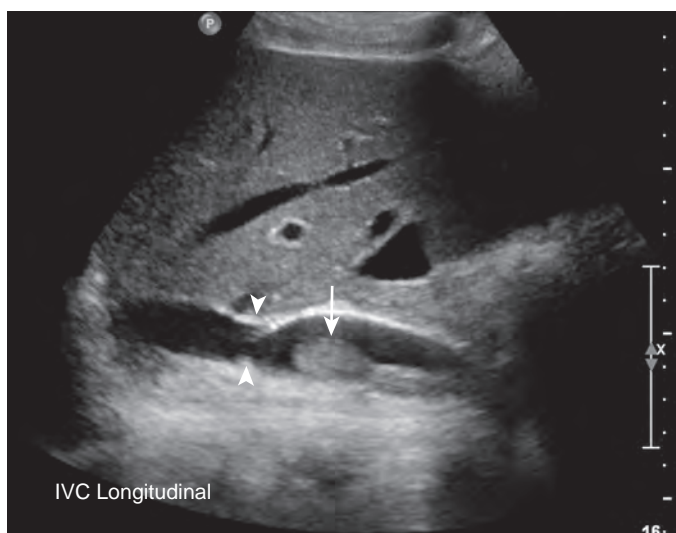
IVC thrombosis. Gray-scale ultrasound image shows nonocclusive echogenic caval thrombus (arrow) adjacent to the caudal IVC anastomosis (arrowheads) in a patient who had end-to-end IVC anastomosis.
